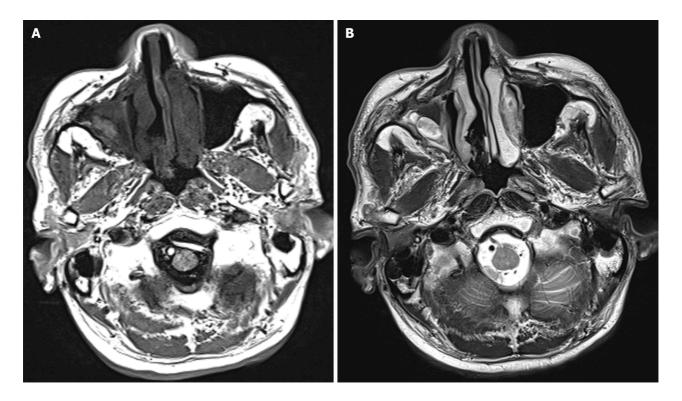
Weighted magnetic resonance imaging. A: An axial T1-weighted magnetic resonance imaging (MRI) shows an iso-intense signal lesion in the right nasal cavity; B: The hypo-intense signal intensity lesion on T2-weighted MRI.
